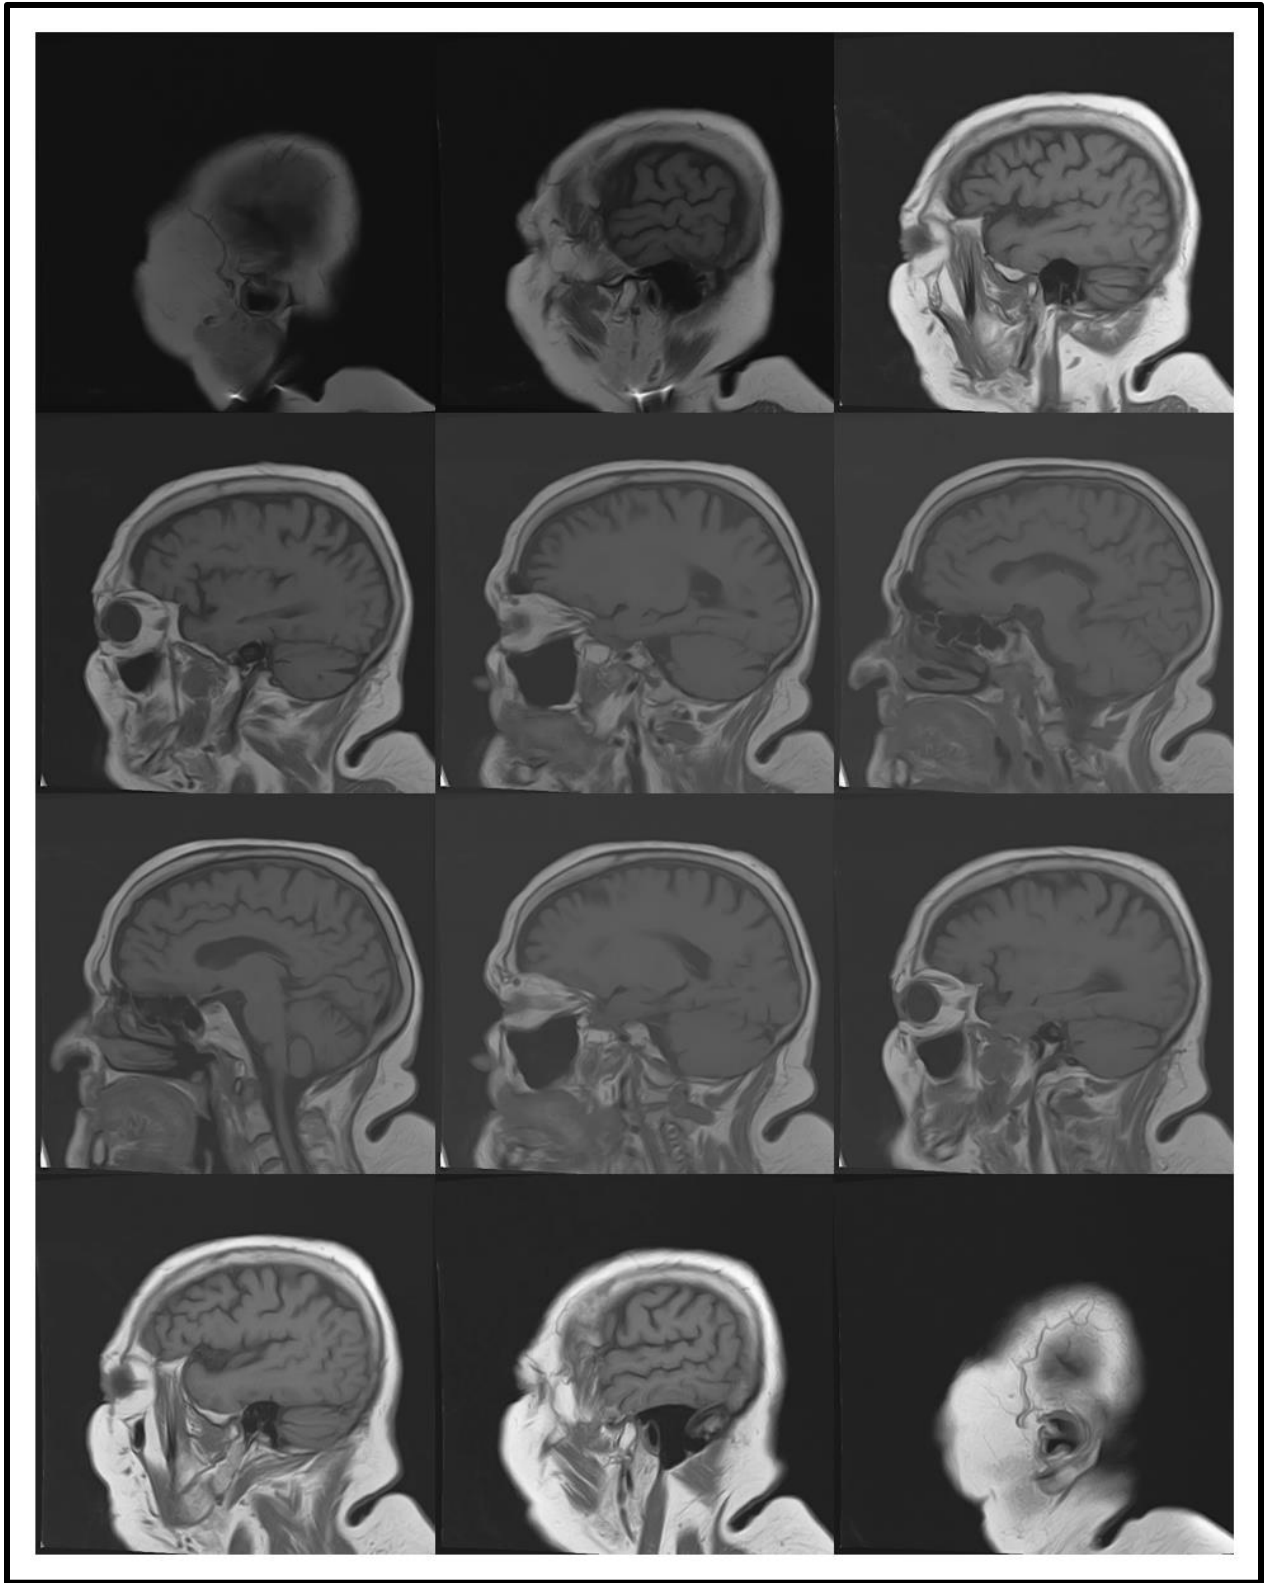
Case 2 MRI Scan Input
